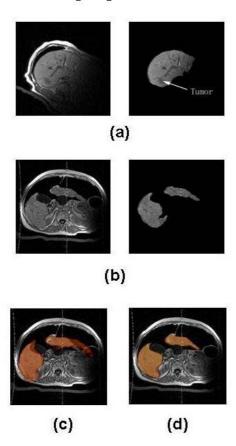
Example 2. (a) Open MR image and its segmented liver image; (b) CT image and its segmented liver image; (c) rigid registration result; (d) FFD-based non-rigid registration result.
